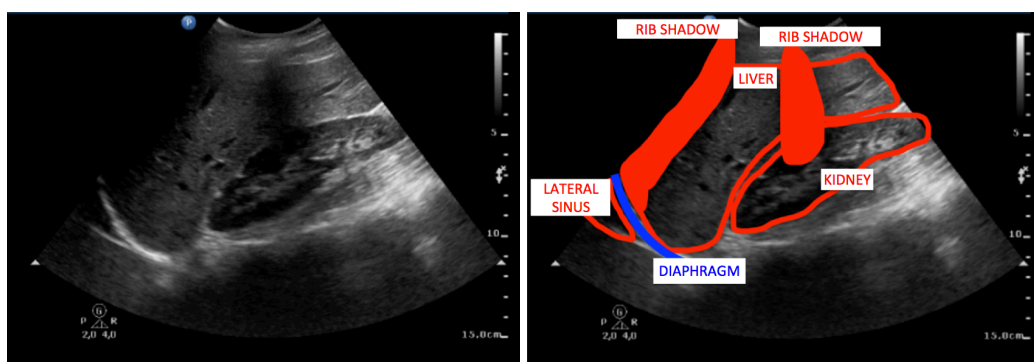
Ultrasonographic image of the right kidney.
